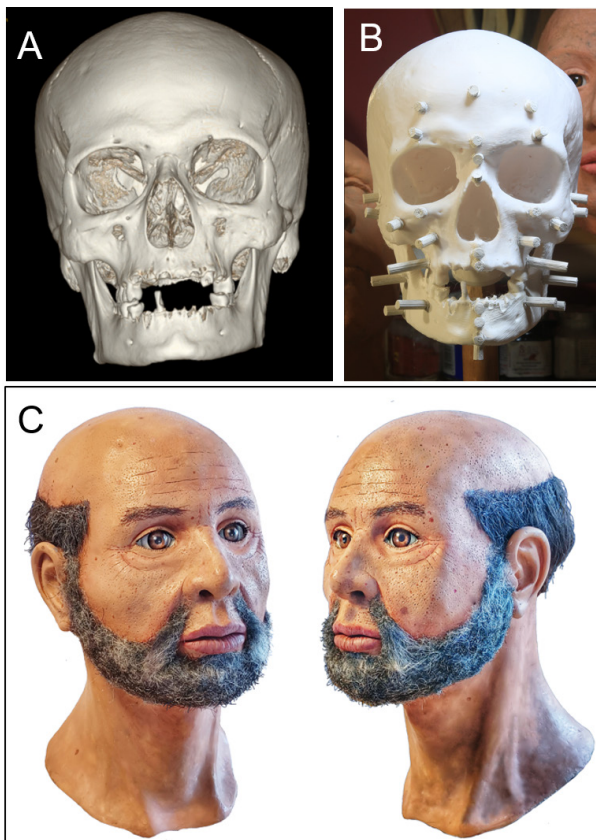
Facial reconstruction of Saint Ceccardo. A: 3D rendering from CT images; B: plastic printed skull during the first phases of facial reconstruction; C: result of the Saint's face.
